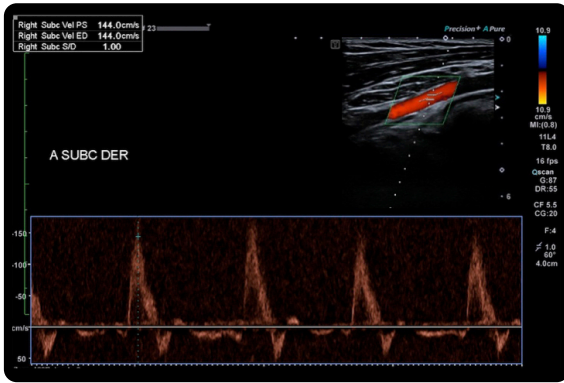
Doppler ultrasound of arterial vessels of the right upper limb. Patent subclavian artery, with three-phase, antegrade, high resistance spectra, within normal limits.
